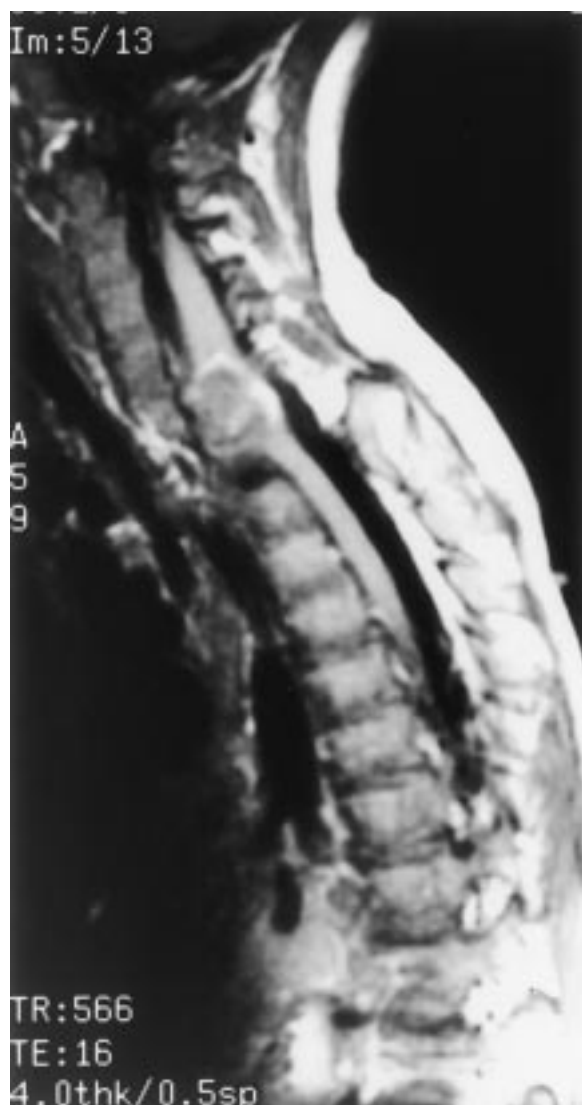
Sagittal, enhanced T1 weighted MRI image of child with cervical neurenteric cyst and multiple vertebral body abnormalities.
